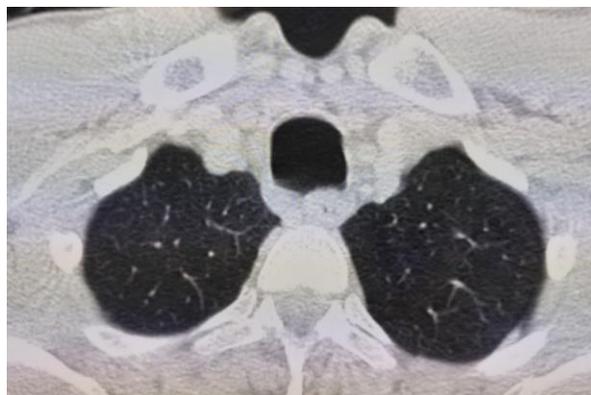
CT image of transverse section of lung showing dilated trachea
